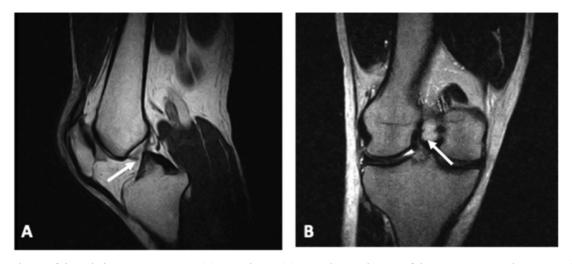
Simple MRI of the right knee in T2 sequence. (A) Sagittal view; (B) Coronal view. Thinning of the anterior cruciate ligament is observed.
